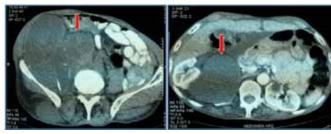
Axial computed tomography images showing the size of the tumor and its mass effect to the right kidney and the small intestine.
